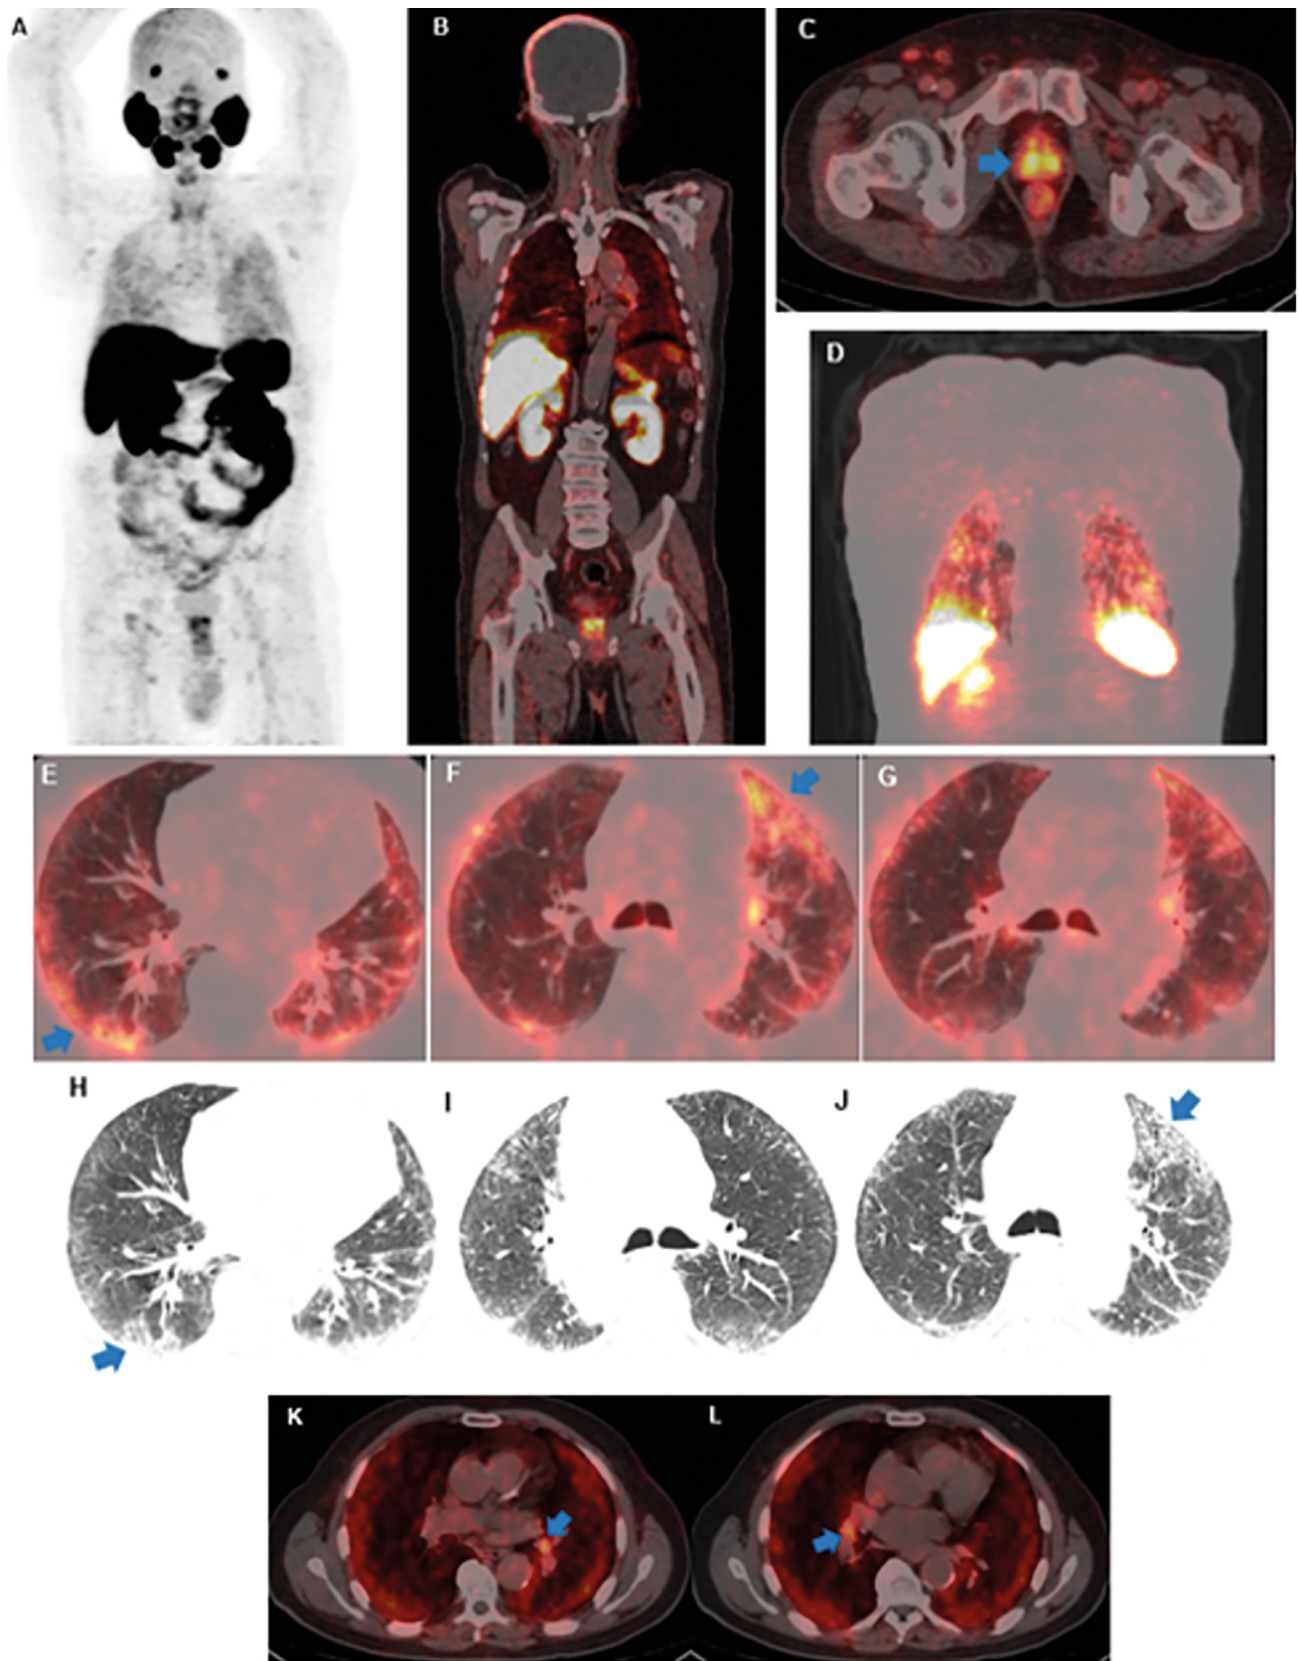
[¹⁸F]F-PSMA-1007 PET/CT whole body maximum intensity projection image (A) coronal fused image (B) fused axial image, primary prostate adenocarcinoma (arrow) (C). Fused [¹⁸F]F-PSMA-1007 PET/CT coronal image (D) and fused axial images (E–G) demonstrate bilateral lung [¹⁸F]F-PSMA-1007 uptake (arrow). Axial CT images show lung ground-glass opacities (arrows) (H–J). Fused axial [¹⁸F]F-PSMA-1007 PET/CT images show bilateral pulmonary hilar lymph node uptake (arrows) (K, L)
